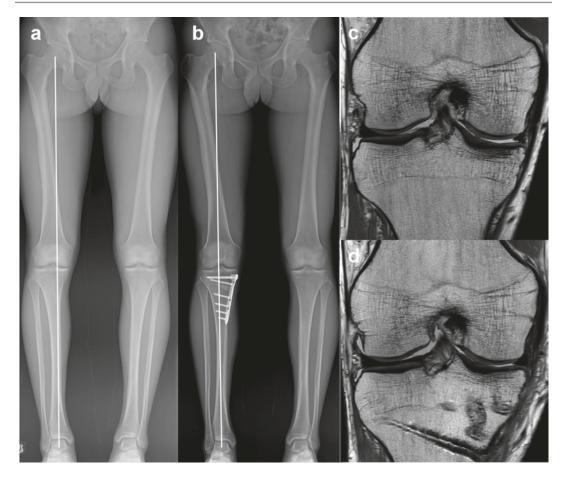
Pre- and Postoperative long-standing hip-kneeankle (HKA) radiographs and magnetic resonance imaging (MRI) scans of a 27-year-old male patient who underwent right medial meniscal allograft transplantation. a Preoperative long-standing HKA radiograph showed varus alignment of right lower extremity, and the weight-bearing line fell into the medial
